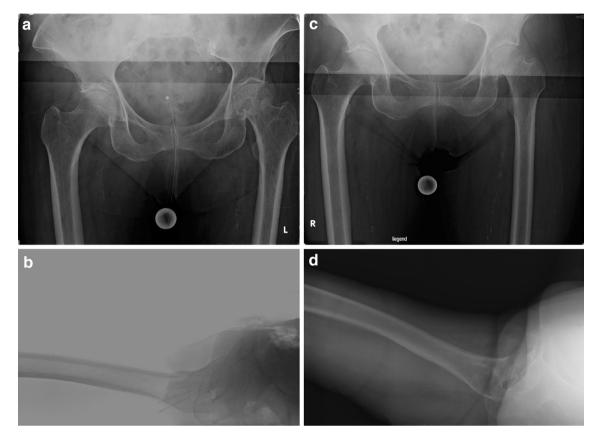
Primary non-operative treatment of a 75 years old female patient, initial AP (a) and axial (b) X-ray after trauma, classified as Garden I. AP (c) and axial (d) X-ray after pain exacerbation and secondary displacement
